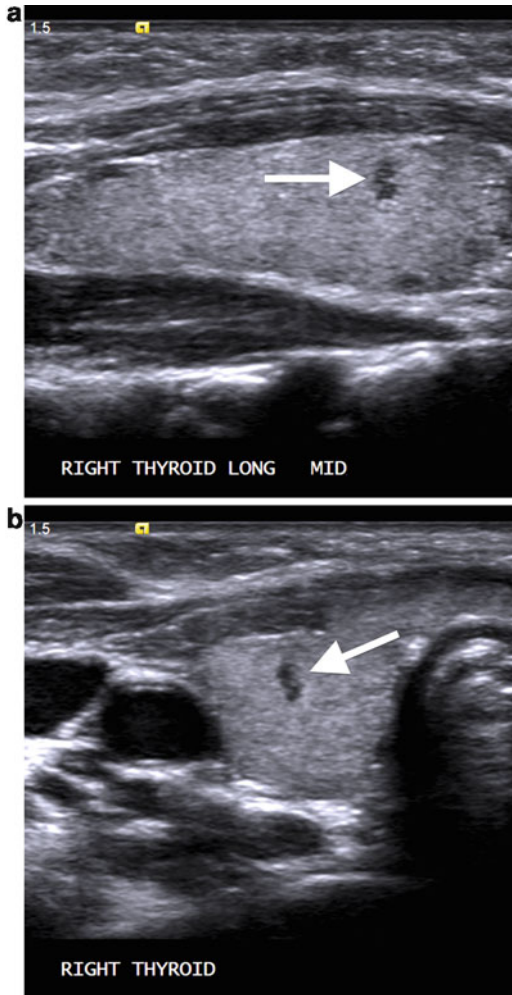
Benign thyroid cyst in trisomy 21. Longitudinal (a) and transverse (b) ultrasound images in a 26-month-old boy with trisomy 21 shows the typical appearance of a very small hypoechoic cyst (arrows) seen in patients with Down syndrome. Note lack of significant posterior acoustic enhancement because these cysts are so small.
